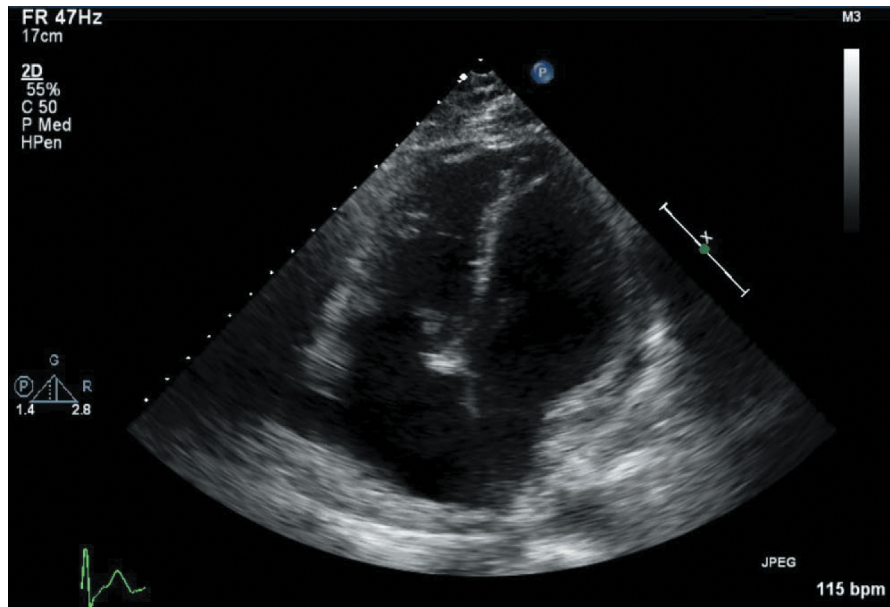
Tricuspid valve vegetation on transthoracic echocardiogram on hospitalization day 5.
